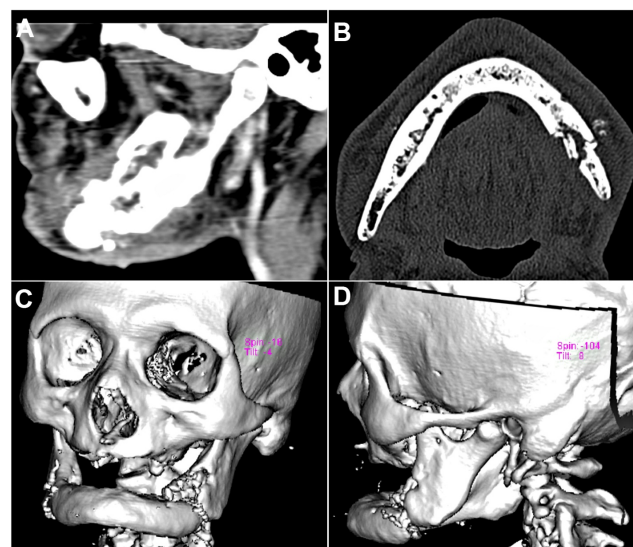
(A,B) Ill-defined lytic areas seen involving both the inner and outer cortices of the mandible. Irregular destruction of the trabecular pattern of the medullary cavity with multiple cortical breaks was noted in the posterior two-third of the left body of the mandible; (C,D) 3D Reformatting of the CT scans with clear visualization of the displaced pathological fracture of the left body of mandible.
